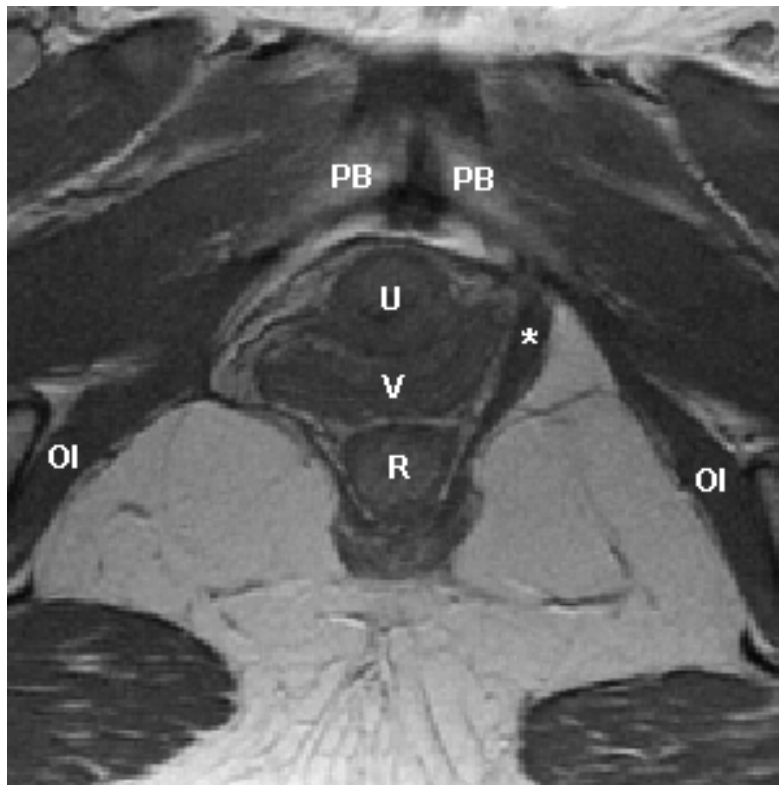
Axial proton density MR image of a woman with a right unilateral defect. The left levator ani muscle is intact (denoted by *) while the right side portion of the muscle is missing. PB denotes pubic bone; U: urethra; V: vagina; R: Rectum; OI: obturator internus muscle.
